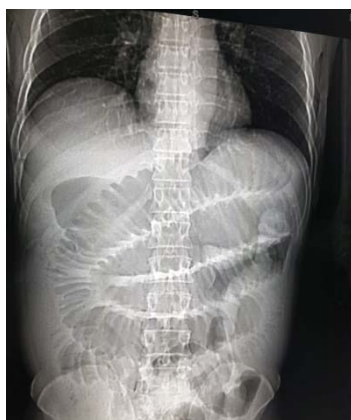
X-ray abdomen supine posture showing multiple dilated bowel loops.
